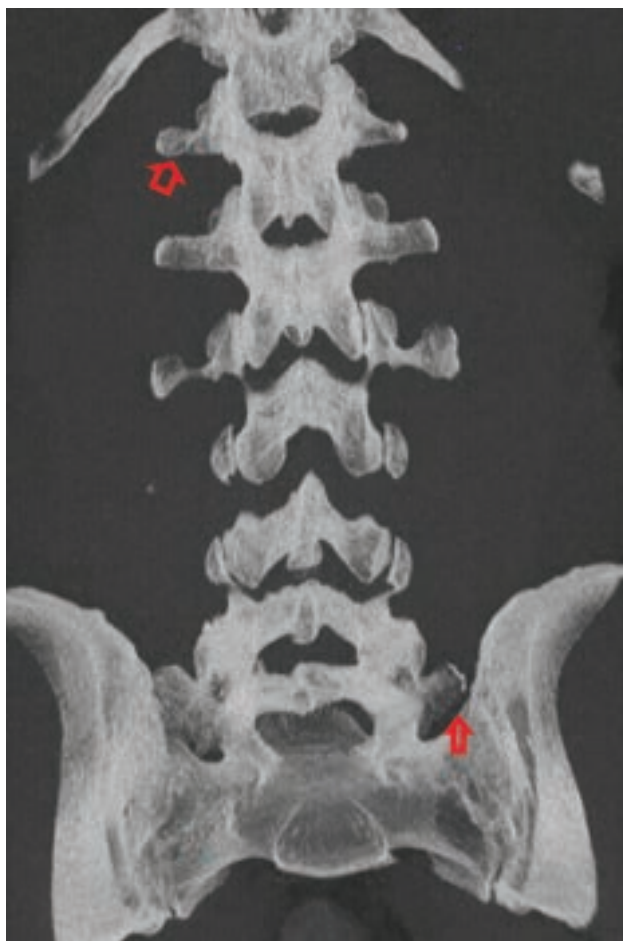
Example of thoracolumbar and lumbosacral transitional anatomy. Coronal MIP CT image of the lumbar spine demonstrates thoracolumbar and lumbosacral anatomy with an accessory ossification center on the right at T12 (open arrow) as well as a partially sacralized L5 vertebral body with an unfused left transverse process (closed arrow).
